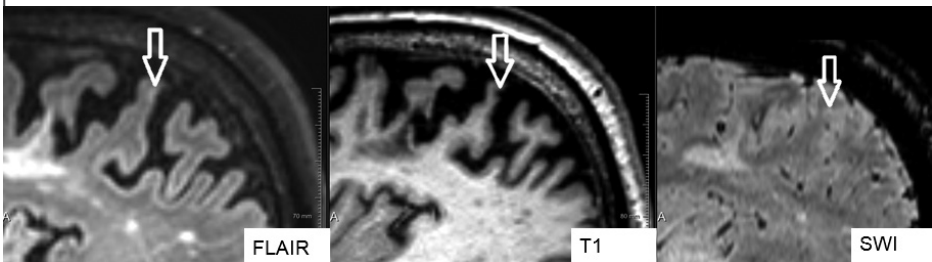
Example of a chronic cortical microinfarcts (white arrow) on 3 tesla MRI, being hyperintense in FLAIR, hypointense on T1 and isointense (e.g. non-distinct) on SWI.
